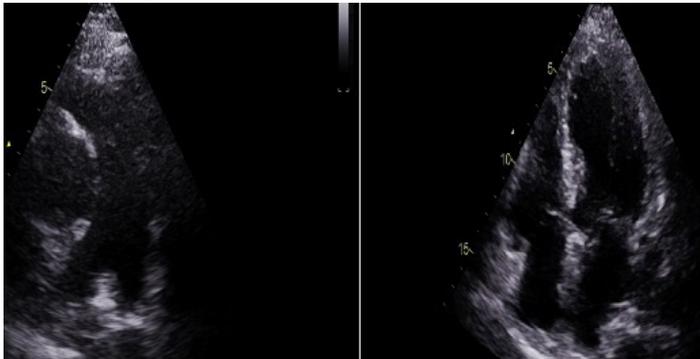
Doppler echocardiography follow up showing missing thrombi in pulmonary embolism (A) and in the right auricle (B).
